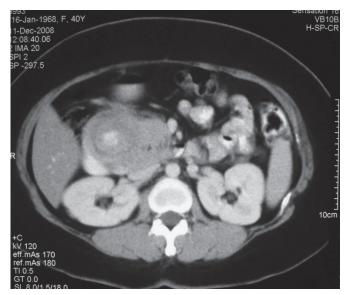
CT scan showed a whorled tumour at the periampullary region
